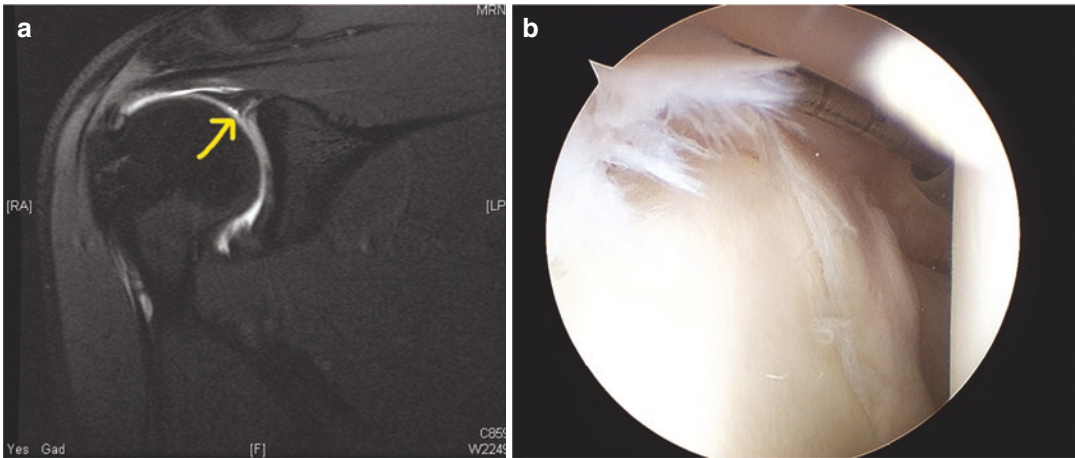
SLAP Lesion—MRI (a) and arthroscopic photo (b) of SLAP lesion in a professional women's tennis player. (Images used with permission from Marc R. Safran, MD)
